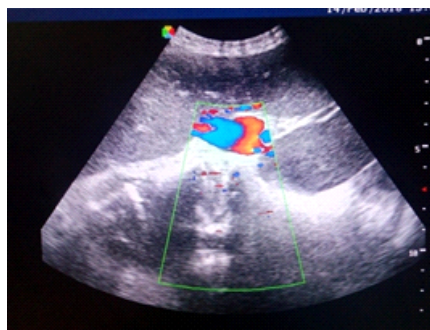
Transabdominal ultrasound of left iliac fossa showing an echopoor sac at splenic hilum (seen in fig 2a) showing ying-yang pattern of flow on color Doppler (fig 2b) suggestive of pseudoaneurysm of splenic artery.
